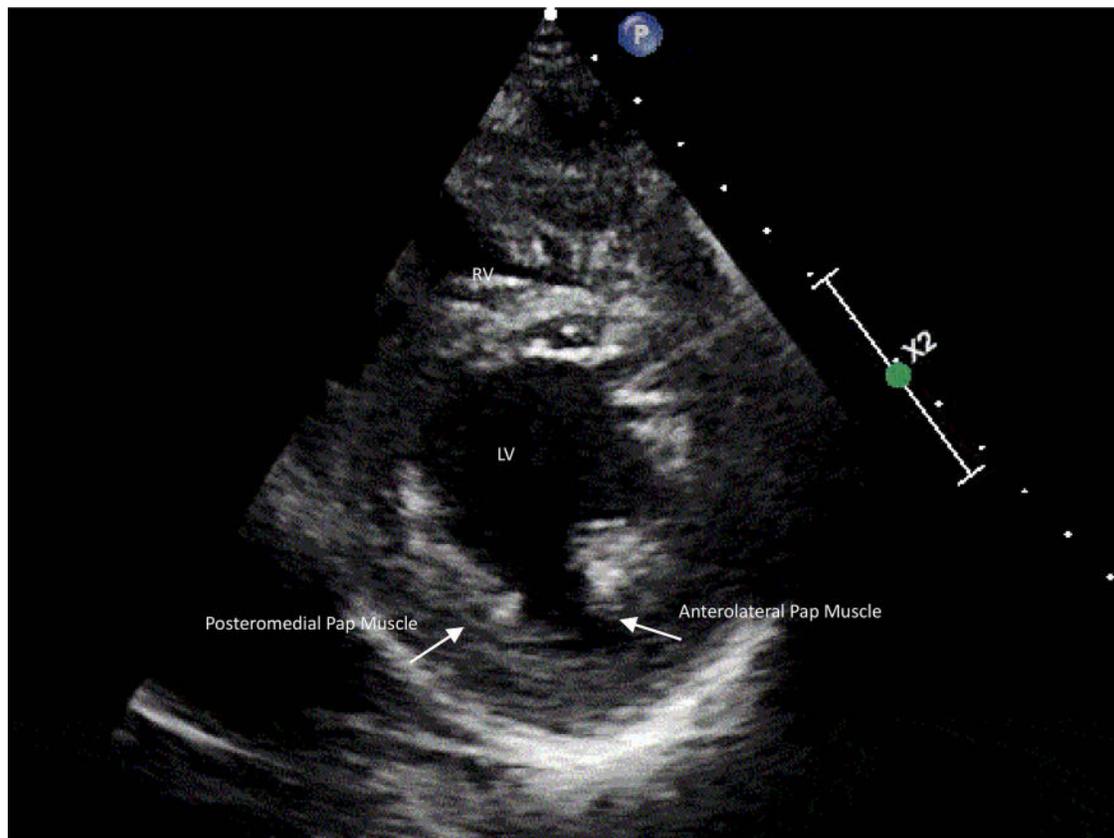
Parasternal short-axis (PSAX) midpapillary view.⁴
